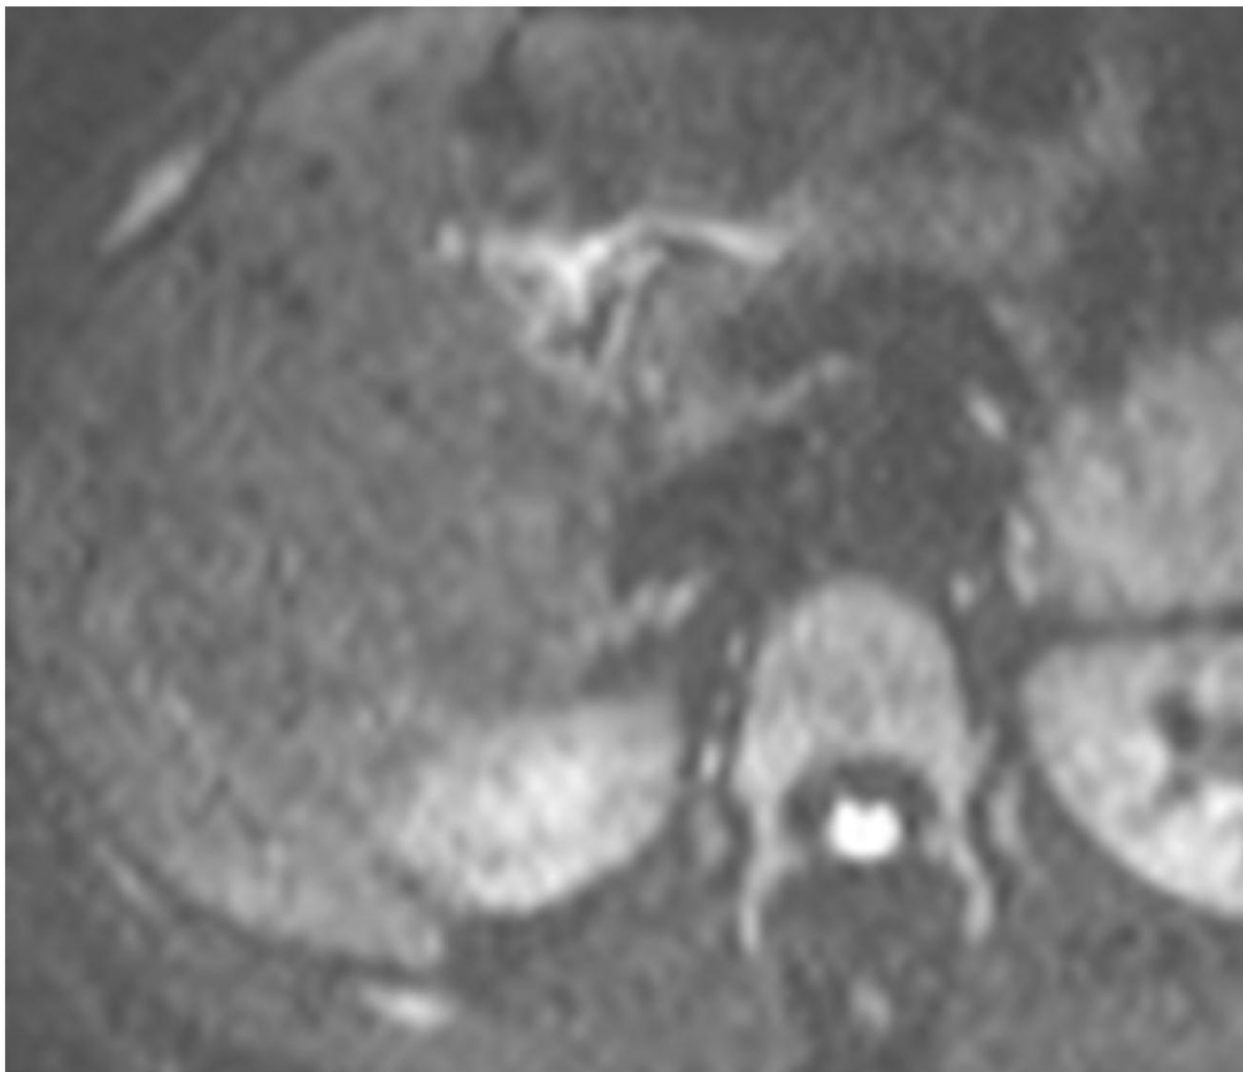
DW MRI. HA shows no restricted diffusion at b-value=400.
